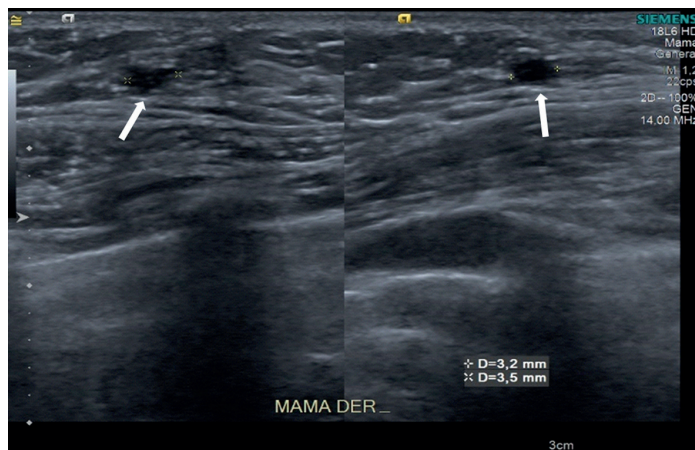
Right breast ultrasound displayed diffuse hypoechoic bilateral fibroglandular tissue, poorly vascularized, measuring 9 × 5 × 3 mm. In addition, a small simple cyst was found, measuring 3.5 mm.
